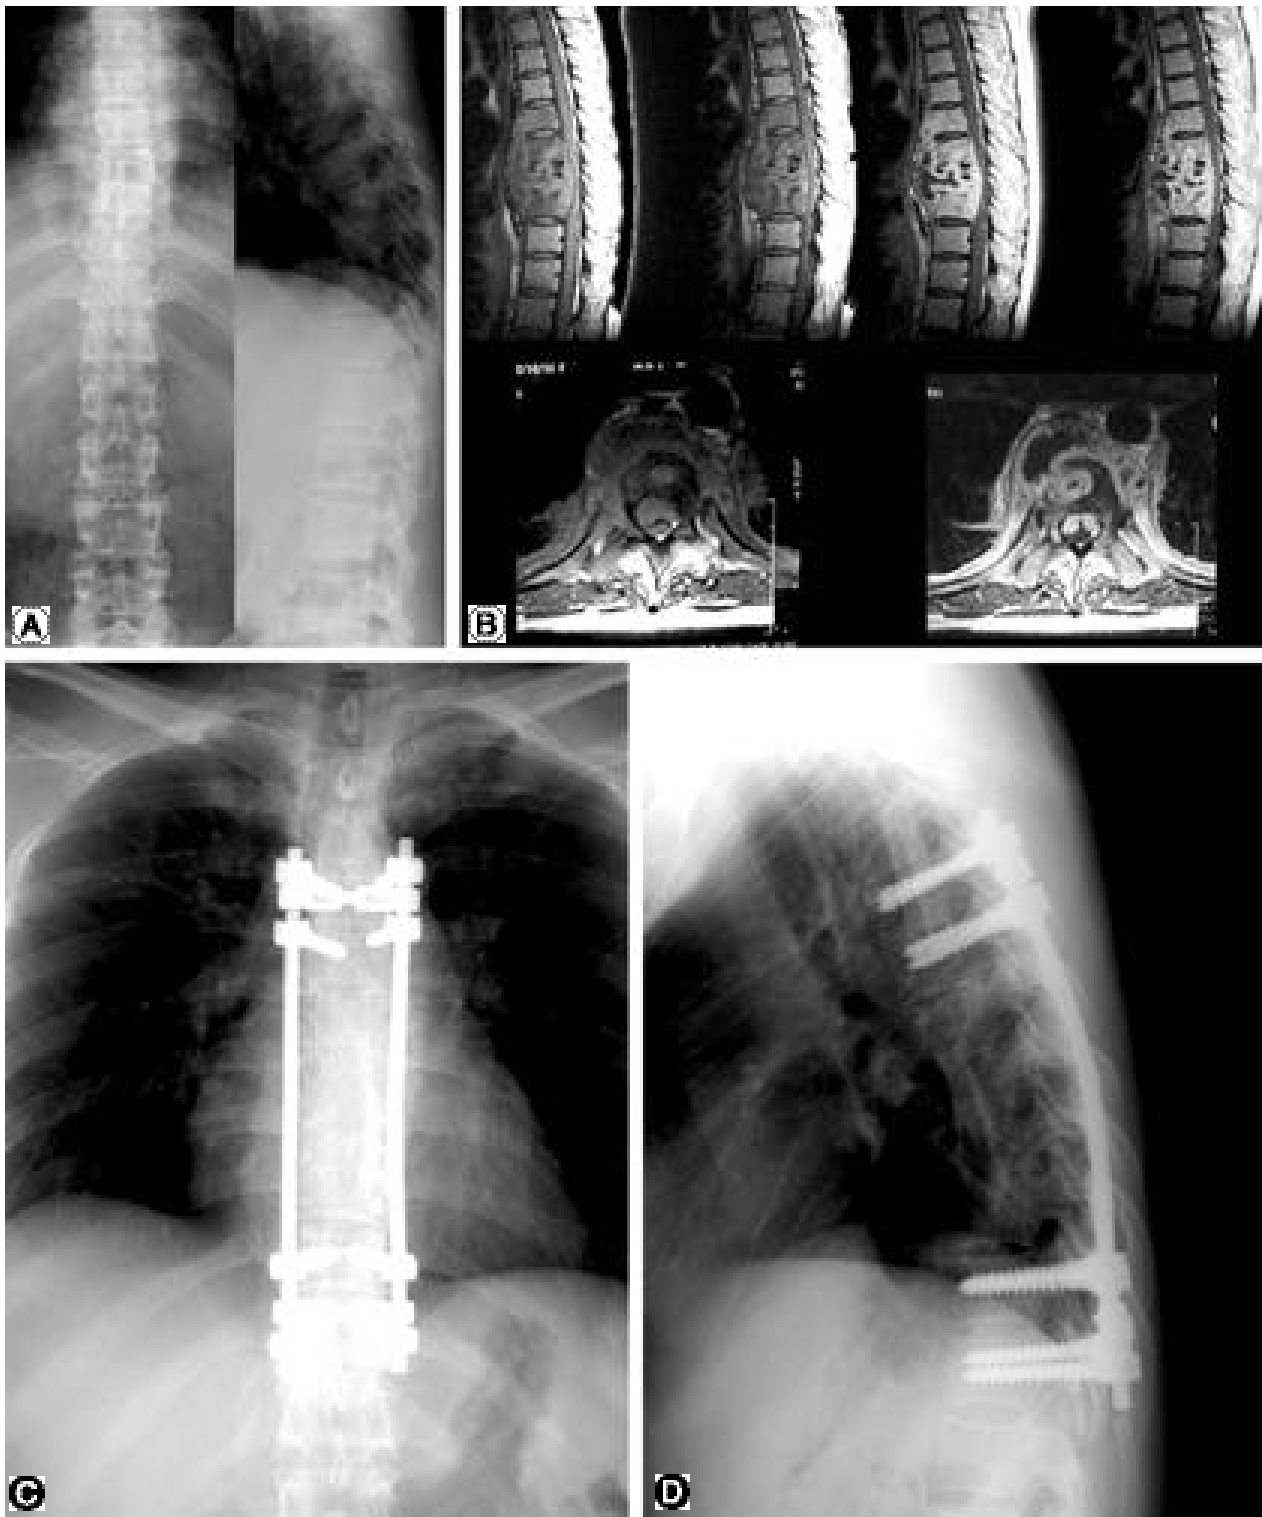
A 31-year-old woman sustained spinal tuberculous spondylitis of thoracic spine and was treated with the combined anterior and posterior technique. (A) Preoperative anteroposterior thoracolumbar spine radiograph shows asymmetrical collapsing of T8 vertebral body and paraspinal soft tissue bulging. On the lateral view, destruction of T8 vertebral body and focal kyphotic angulation was noted. (B) Magnetic resonance images showed extent of the lesion more clearly. Affected segment ranged from T6 to T9. Compression of spinal cord by an epidural mass was also evident. (C)(D) Radiographs obtained at postoperative 1-year follow-up shows solid fusion with pedicle screw instrumentation. Anterior fusion with iliac bone graft was performed from T6 to T9 and pedicle screws were not inserted to the affected vertebra.
